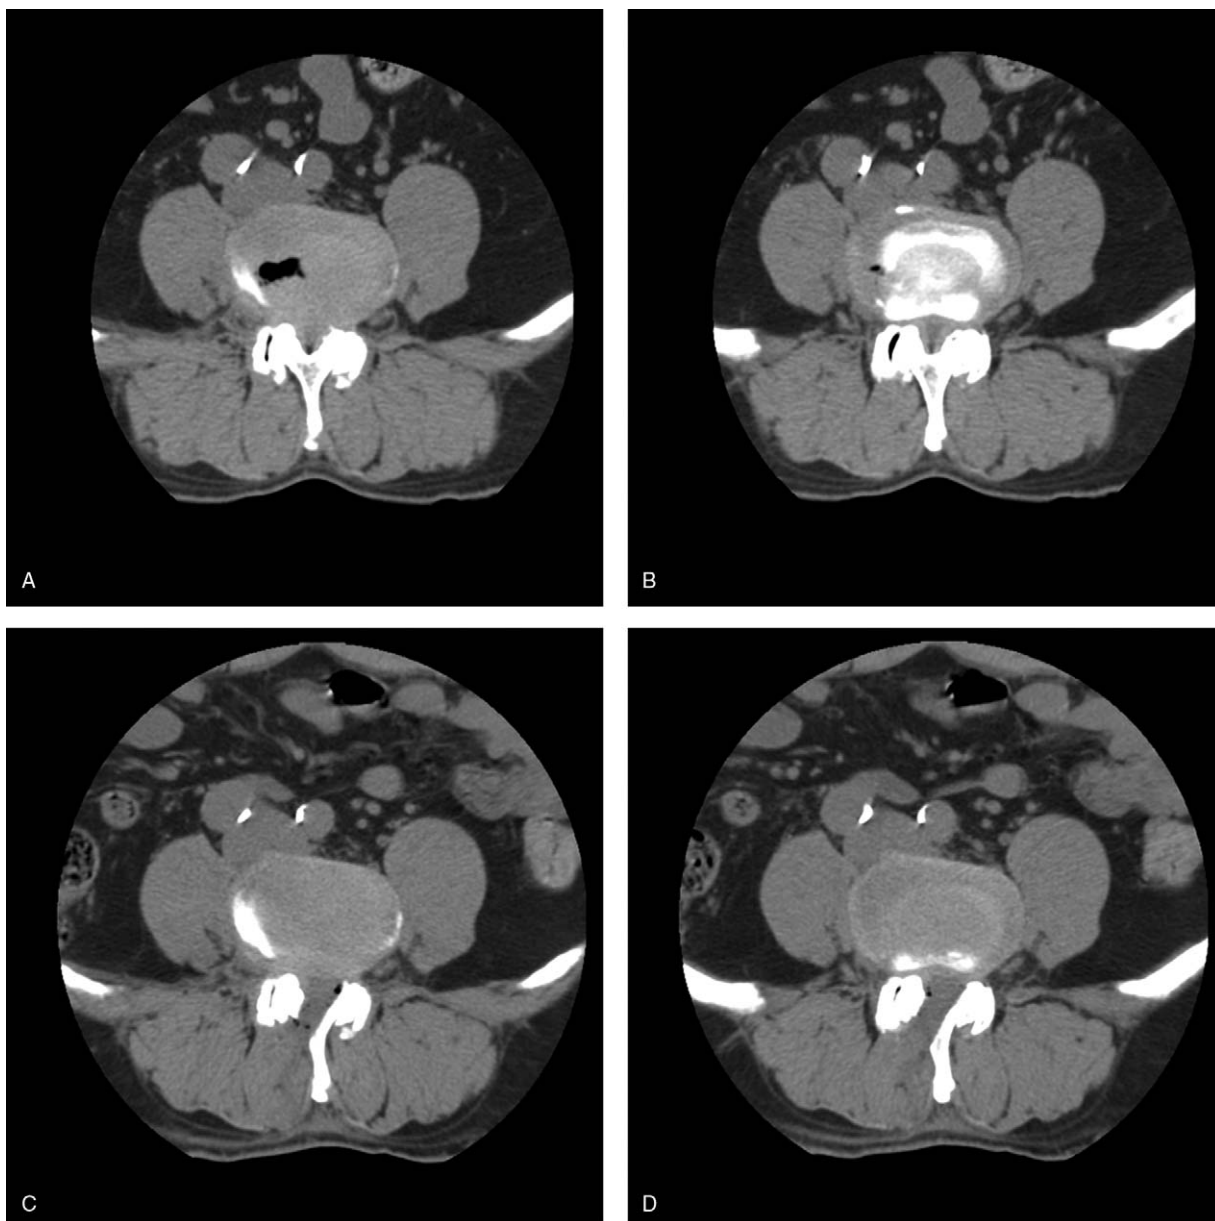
Preoperative and postoperative CT images of 1 patient with LSS. (A and B) preoperative CT scan showing the reduction of lumbar spinal canal volume; (C and D) postoperative CT scan showing the enlargement of lumbar spinal canal volume. CT=computed tomography, LSS=lumbar spinal stenosis.
